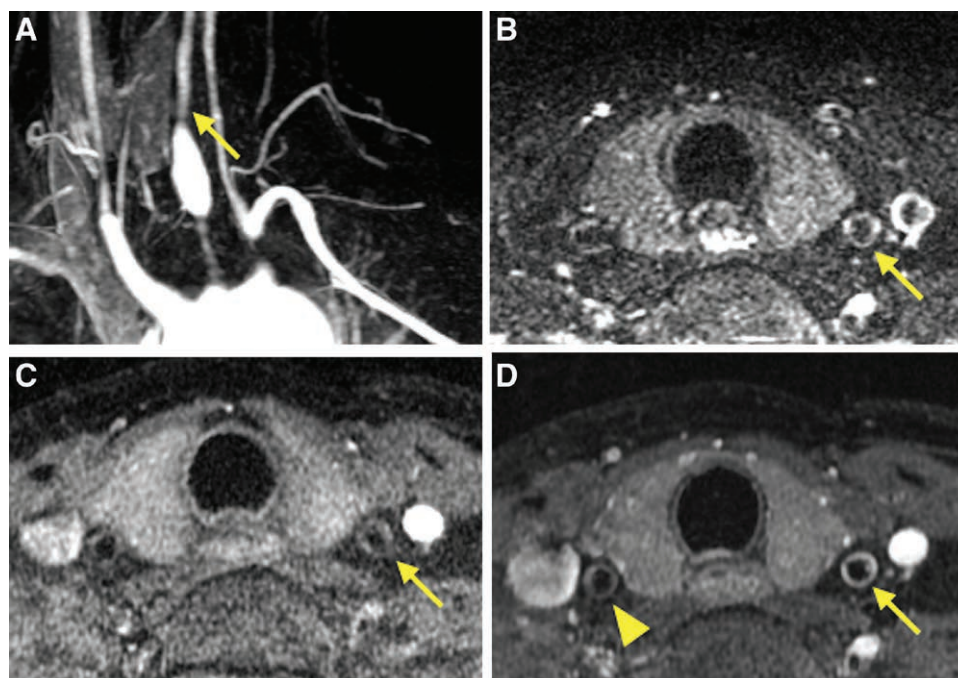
HR-VWI of a 36-year-old female with TA in an acute inflammatory stage. A, Coronal maximum intensity projection (MIP) three-dimensional MR angiogram shows high-grade stenosis of the left CCA (arrow). B, Axial T2-weighted MR image shows iso- to hyperintense signal in the left CCA wall (arrow). C, Axial T1-weighted MR image shows iso-intense signal of a thickening vessel wall of the left CCA (arrow). D, Contrast-enhanced, axial T1-weighted MRI shows concentric wall thickening and enhancement of the left proximal CCA (arrow), suggestive of an acute inflammatory stage. The chronic inflammatory lesion in the right CCA at the same level shows slight stenosis and nearly no enhancement (arrowhead). CCA = common carotid artery; CTA = computed tomography angiography; HR-VWI = high-resolution vessel wall imaging; MR = magnetic resonance; MRI = magnetic resonance imaging; TA = Takayasu arteritis.
